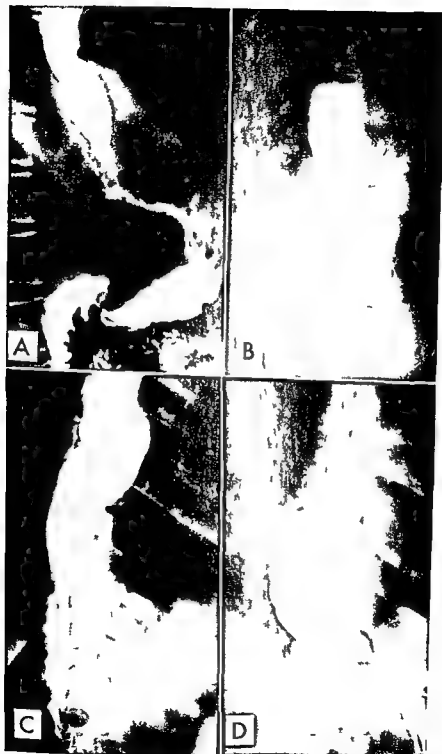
Series of roentgen films showing the evolution of a case of achalasia A Appearance in 1942 B 1946 C 1948 D 1951
